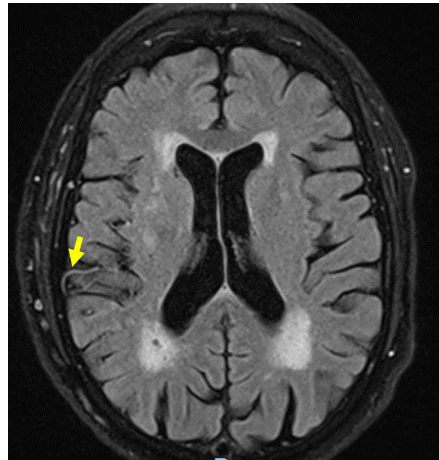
Axial FLAIR MRI demonstrates a linear, serpiginous hyperintensity within the right perisylvian cortical sulci (yellow arrow), consistent with FLAIR vascular hyperintensity (FVH). This appearance indicates slow flow in distal right MCA (M2/M3) branches.
